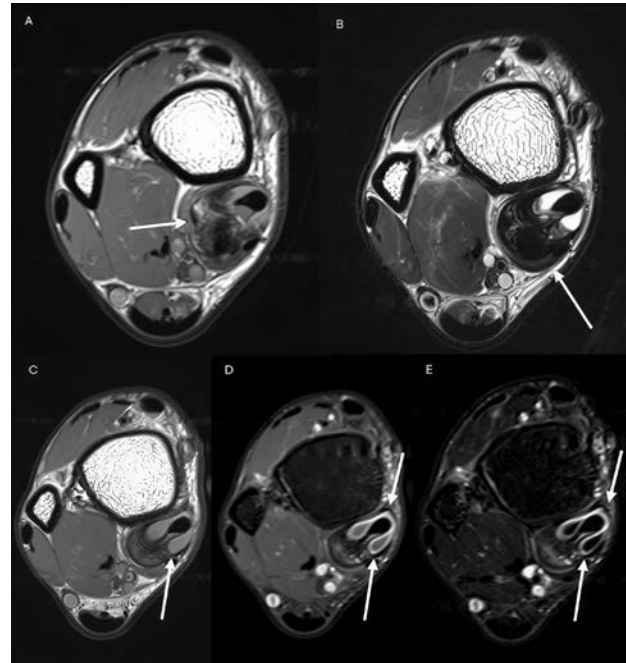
MRI of the ankle demonstrates a diffuse extra-articular TSGCT involving the tendon sheath of the tibialis posterior tendon. The lesion shows irregular delineated soft-tissue proliferation of low-to-intermediate signal on T1- and T2-WI (arrows, A and B). There is also heterogeneous enhancement of the tendon sheath and surrounding fatty tissue (arrows) on T1-WI (C) with gadolinium contrast (D) and subtraction images (E).
